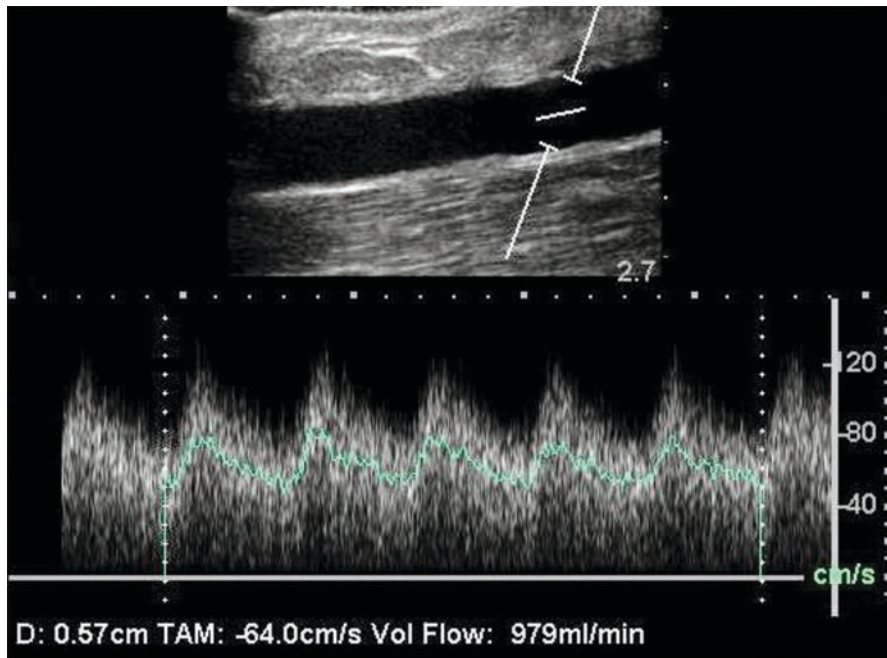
Doppler ultrasound evaluation of AVF flow. Doppler ultrasound may be employed to measure the fistula flow non-invasively. This measurement may supplement the findings of physical examination and ultrasound imaging
